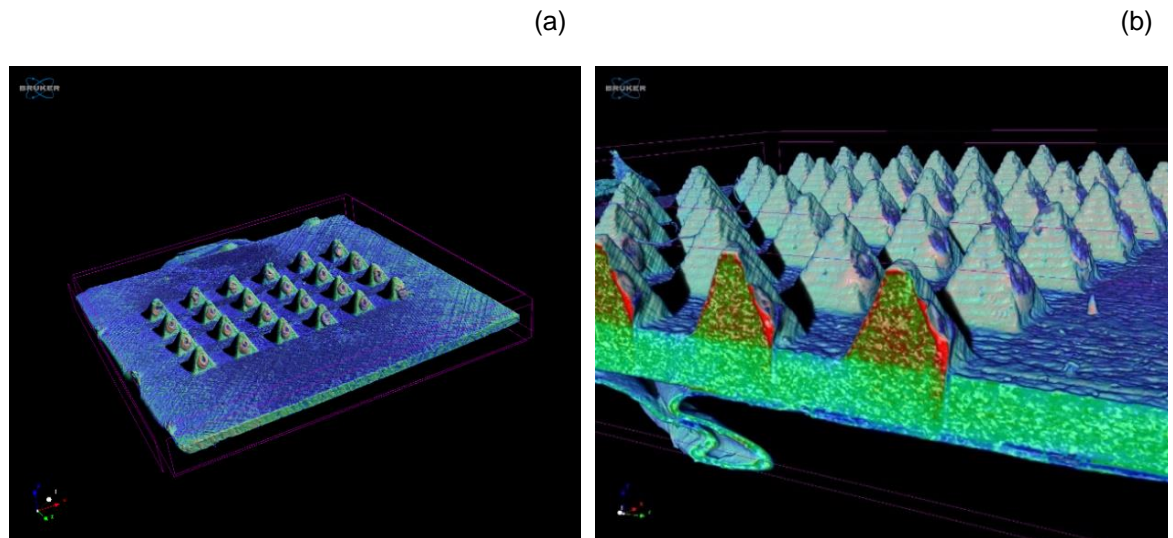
μ -CT scan of the coated pyramid microneedles (a) superior overview and (b) cross-section overview.
